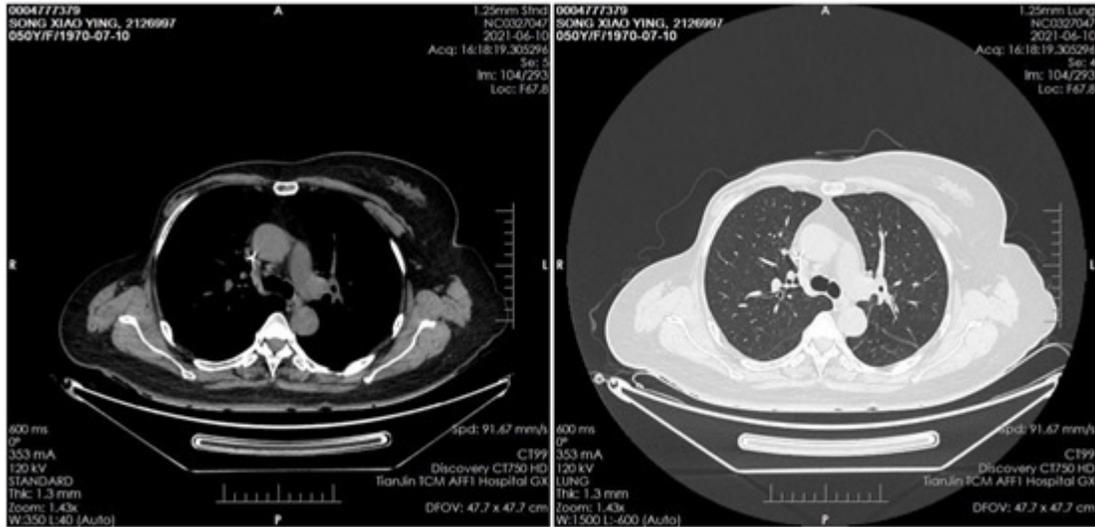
Chest computed tomography after eight circle of endocrine therapy combined with targettherapy (June 10, 2021).
